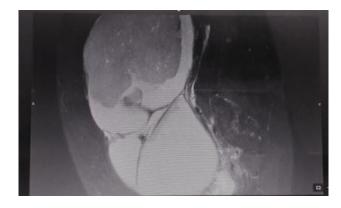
MRI showed multi-loculated cystic lesion.
